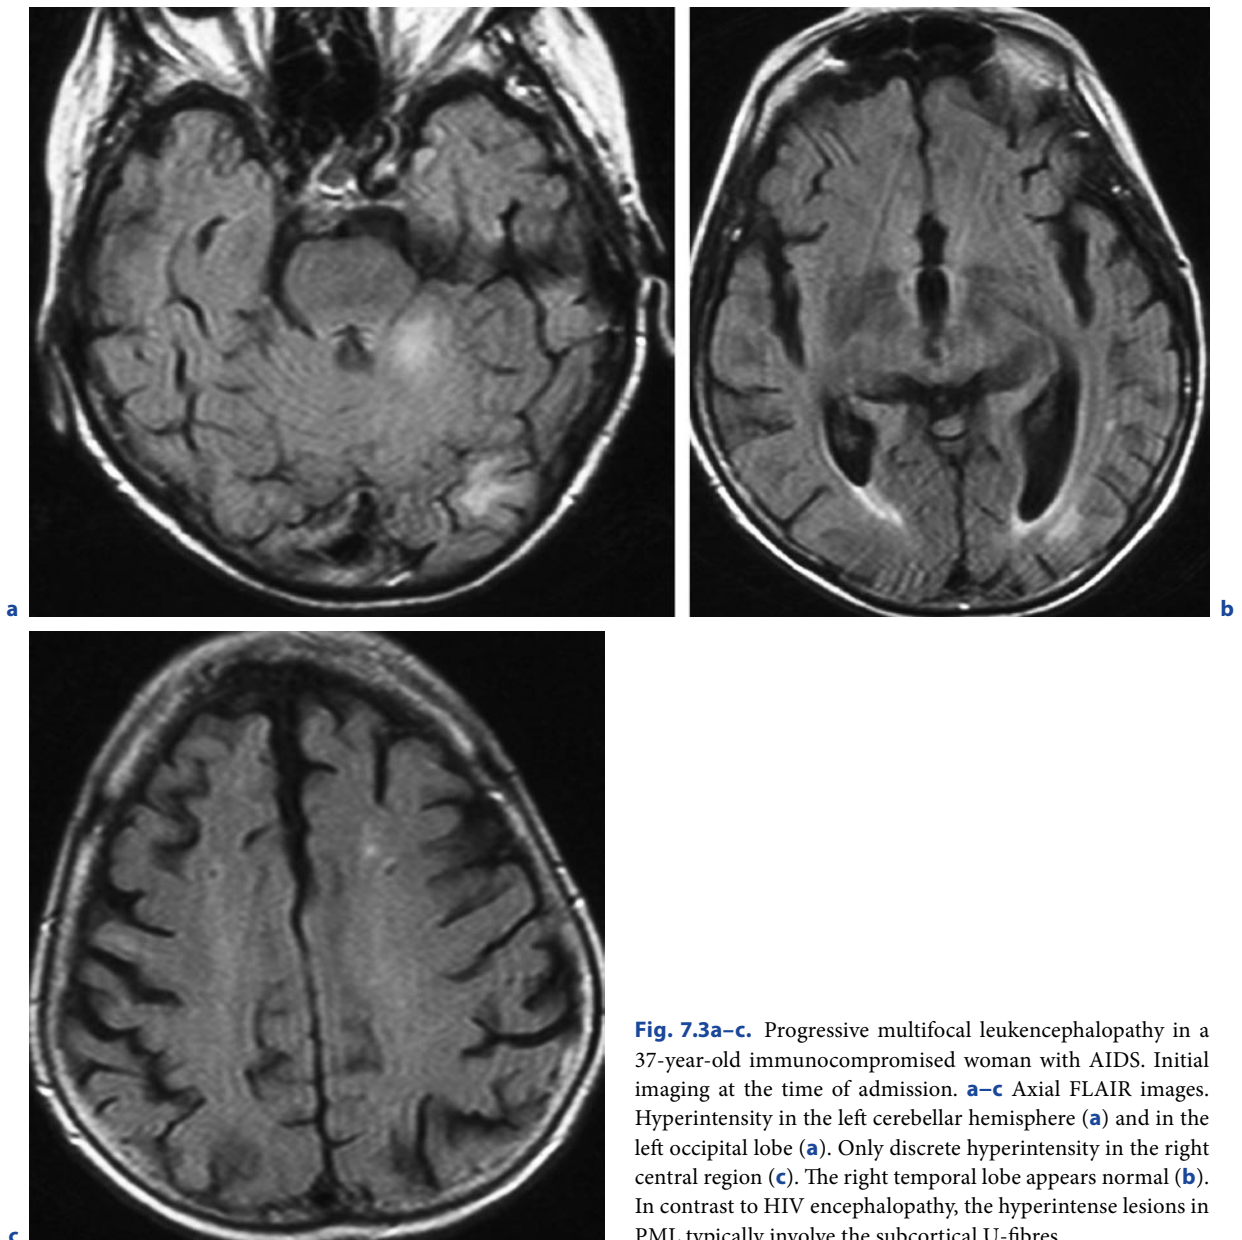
Progressive multifocal leukoencephalopathy in a 37-year-old immunocompromised woman with AIDS. Initial imaging at the time of admission. a–c Axial FLAIR images. Hyperintensity in the left cerebellar hemisphere (a) and in the left occipital lobe (a). Only discrete hyperintensity in the right central region (c). The right temporal lobe appears normal (b). In contrast to HIV encephalopathy, the hyperintense lesions in PML typically involve the subcortical U-fibres
